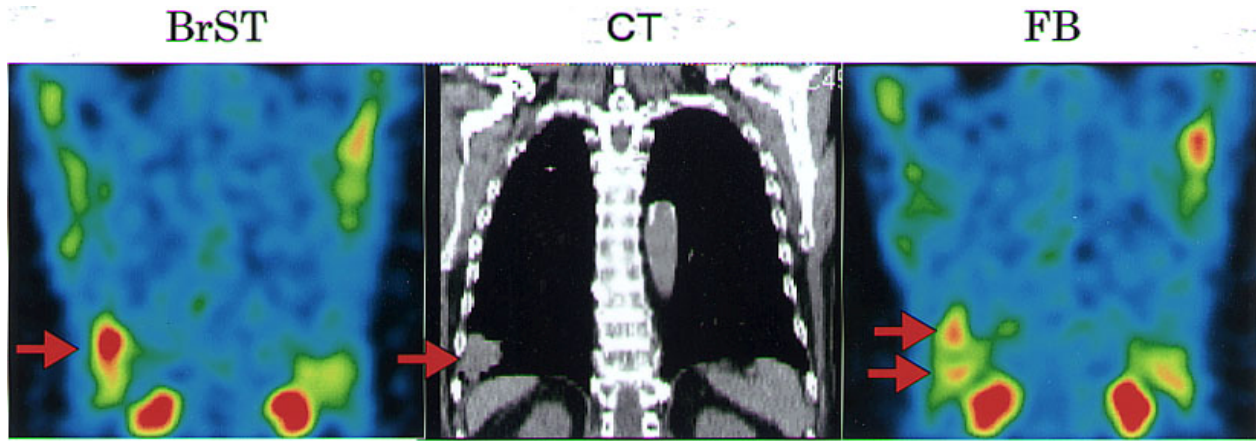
Case 10. Chest CT scanning showed an abnormal shadow measuring 53×39 mm in the right lower lobe. Both of the BrST and FB methods of ^{201}Tl SPECT demonstrated abnormal accumulation (arrow) corresponding to the lesion on the delayed images. However, the accumulation in the FB method was divided into two hot nodules (arrow). This nodule was a non-small cell carcinoma.
